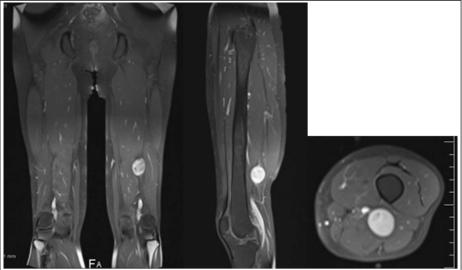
MRI with gadolinium images showing hyperintense lesion on the posterior aspect of the distal aspect of the sciatic nerve measuring  $3.7 \times 2.8 \times 3.2$  cm, 2.5 cm from the bifurcation of the nerve in the apex of the popliteal space.
